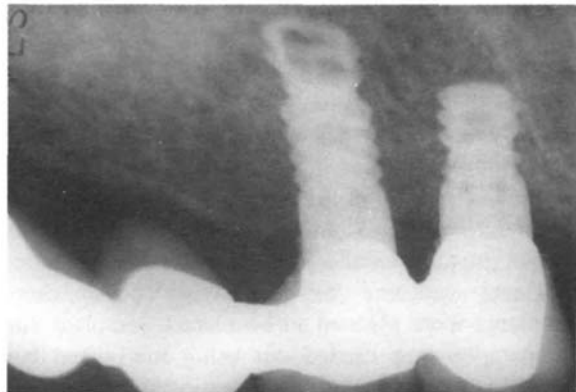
Peri-implant zone radiograph two years later did not show any abnormal changes or radiolucency.
